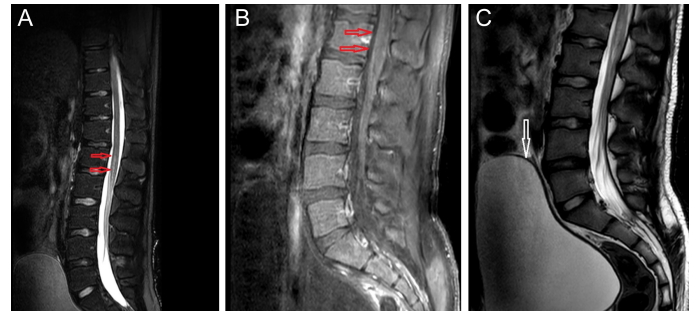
Brain and spinal magnetic resonance imaging (MRI) of the patient. (A) Sagittal view of the lumbar spine post-contrast enhancement. T1 shows no contrast enhancement (red arrows). (B) Short T1 inversion recovery (STIR) sagittal view of the lumbar spine shows hyperintensity suggesting demyelination or transverse myelitis in the lower cord and conus medullaris (red arrows). (C) Sagittal T2-weighted lumbar MRI, the bladder is distended (white arrow, globe).
